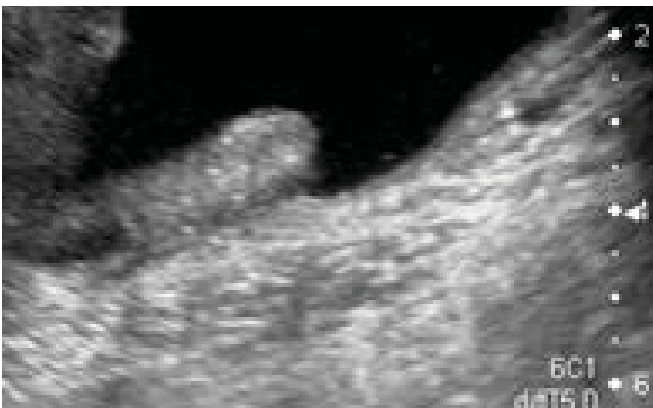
Ascites. Ascites is easy to recognise ultrasonographically. This is non-specific findings but is frequently seen in portal hypertension
